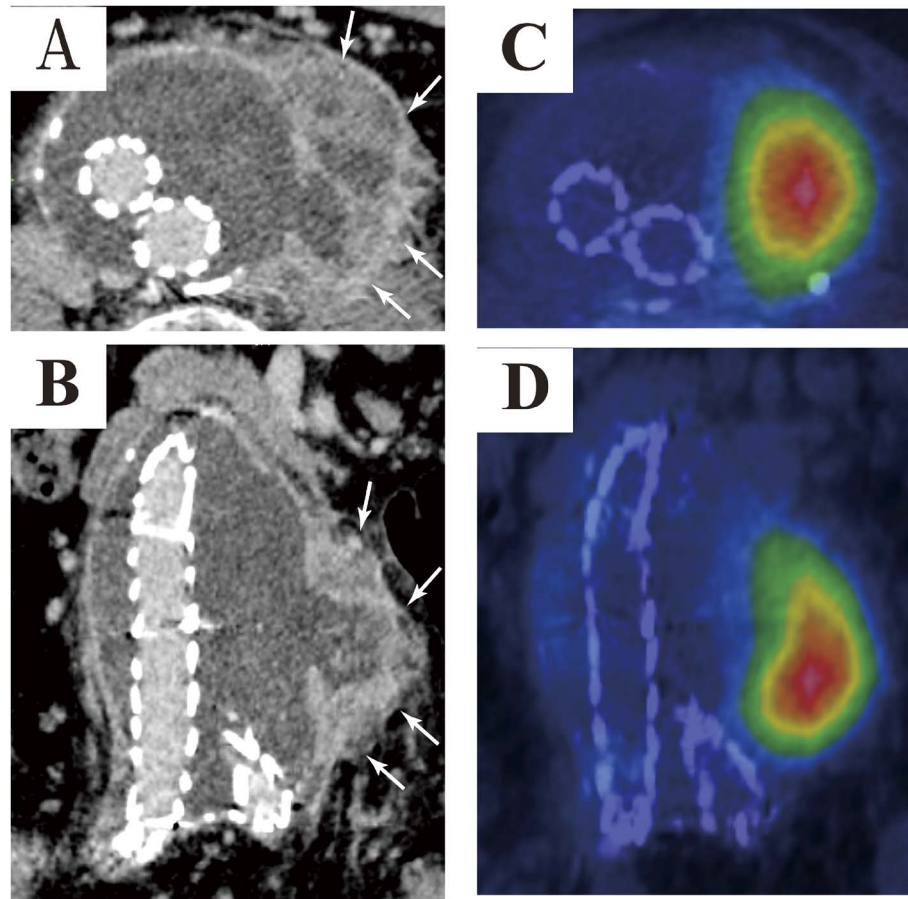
(A, B) Abdominal computed tomographic (CT) scan at 14 months, exhibiting thickening of the aneurysm sac wall (white arrows). No evidence of endoleak formation or stent-graft migration was observed. (C, D) Ga-67-citrate single-photon emission computed tomography (SPECT)/CT fusion images at 15 months demonstrating localized fluid accumulation at the left side of the abdominal aortic aneurysm (AAA) sac. These images show a high level of integration as indicated by the encroachment of the warm colors.
